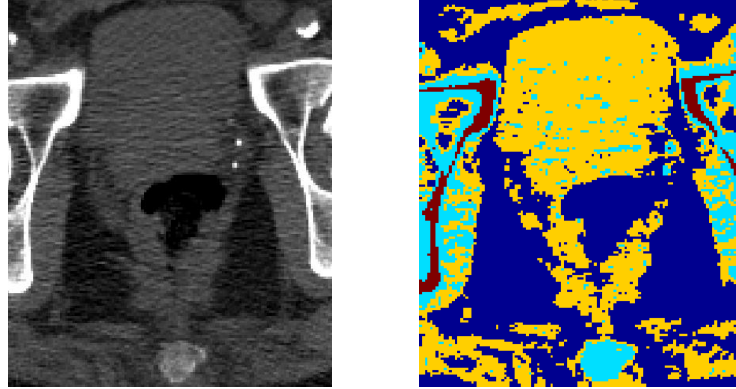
Multiclass texture segmentation of a pelvic CT image using the Gabor wavelet transform.
